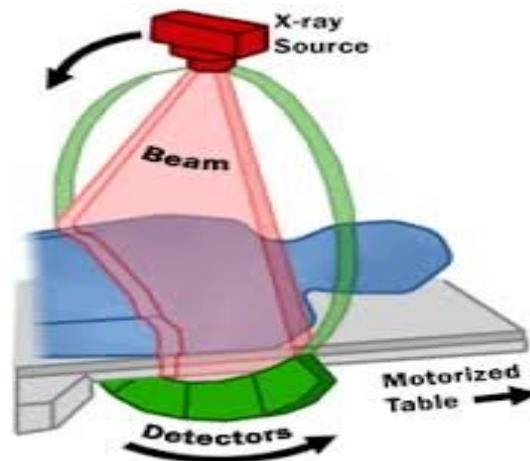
Simple overview of a third generation CT-imaging system (Kalra, M.K, et al 2006)
